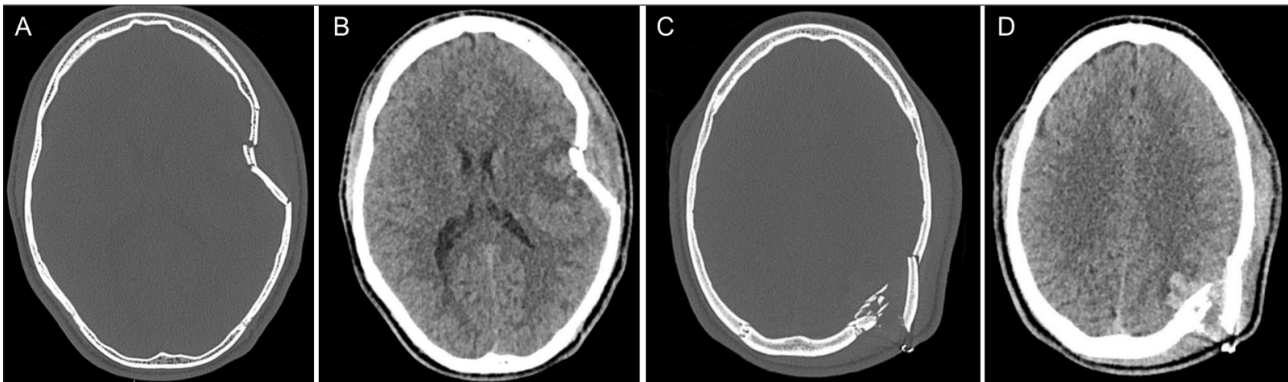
Examples of depressed and elevated skull fractures. A: Axial computed tomography brain (CTB) bone window demonstrating the depressed fracture. B: Axial CTB demonstrating the cranial injury (contusion). C: Axial CTB bone window demonstrating the elevated skull fracture. D: Axial CTB with an elevated bone fracture and intracranial haemorrhagic contusion.
